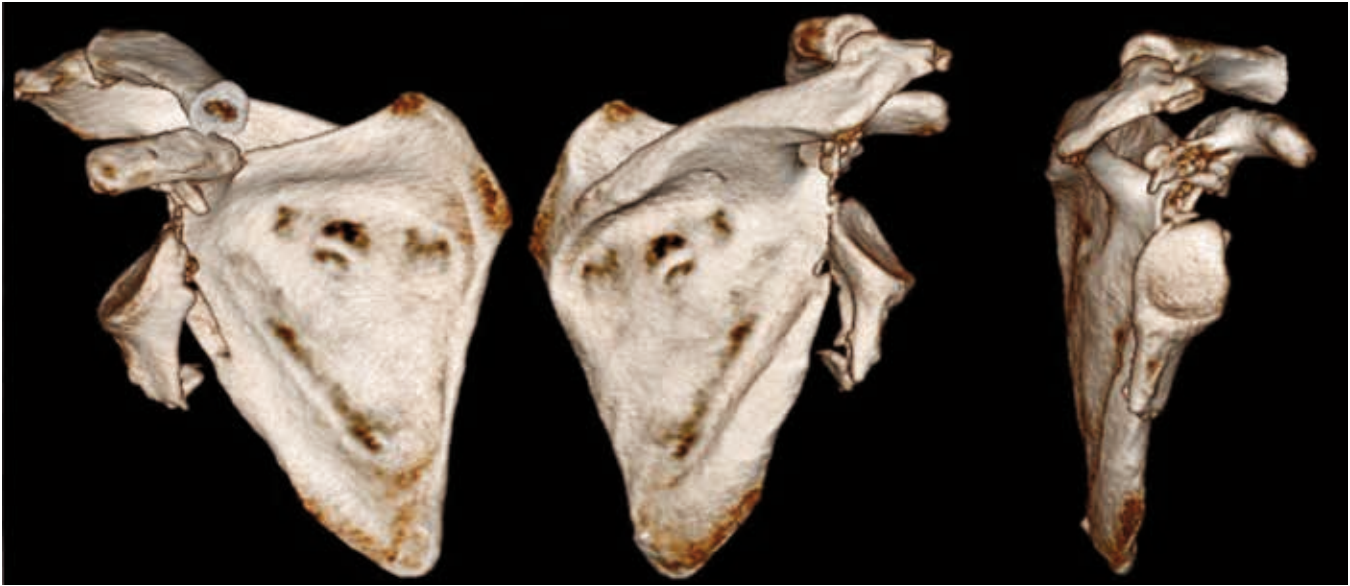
Displaced anatomical neck fracture on 3D CT reconstructions.
